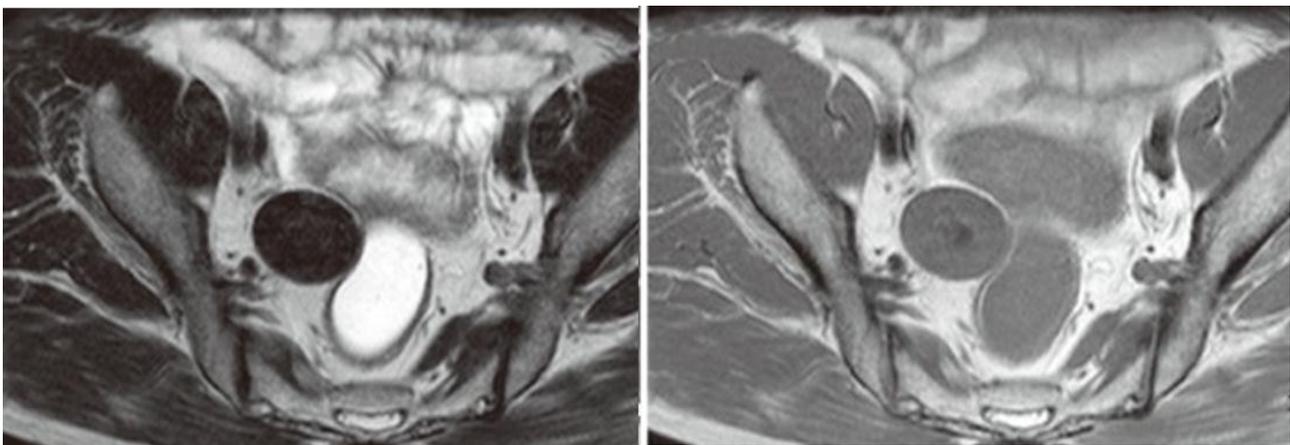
On MRI axial T2WI and T1WI images: well defined ovoid T2 hypointense and T1 isointense lesion with central hypointense area (calcification) in the pelvic cavity on right side. There is change in the position of the lesion is noted from RIF(in CT) into the pelvic cavity on the right side (in MRI).
